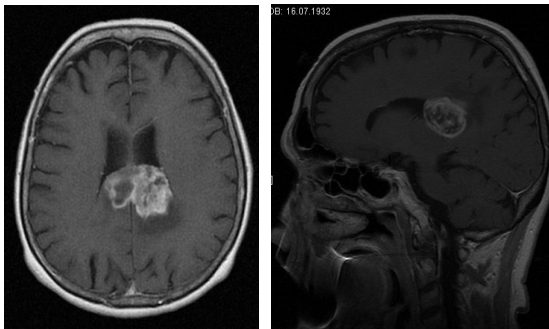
Preoperative enhanced MRI and postoperative CT scan of a completely removed Glioblastoma Multiforme of corpus callosum
